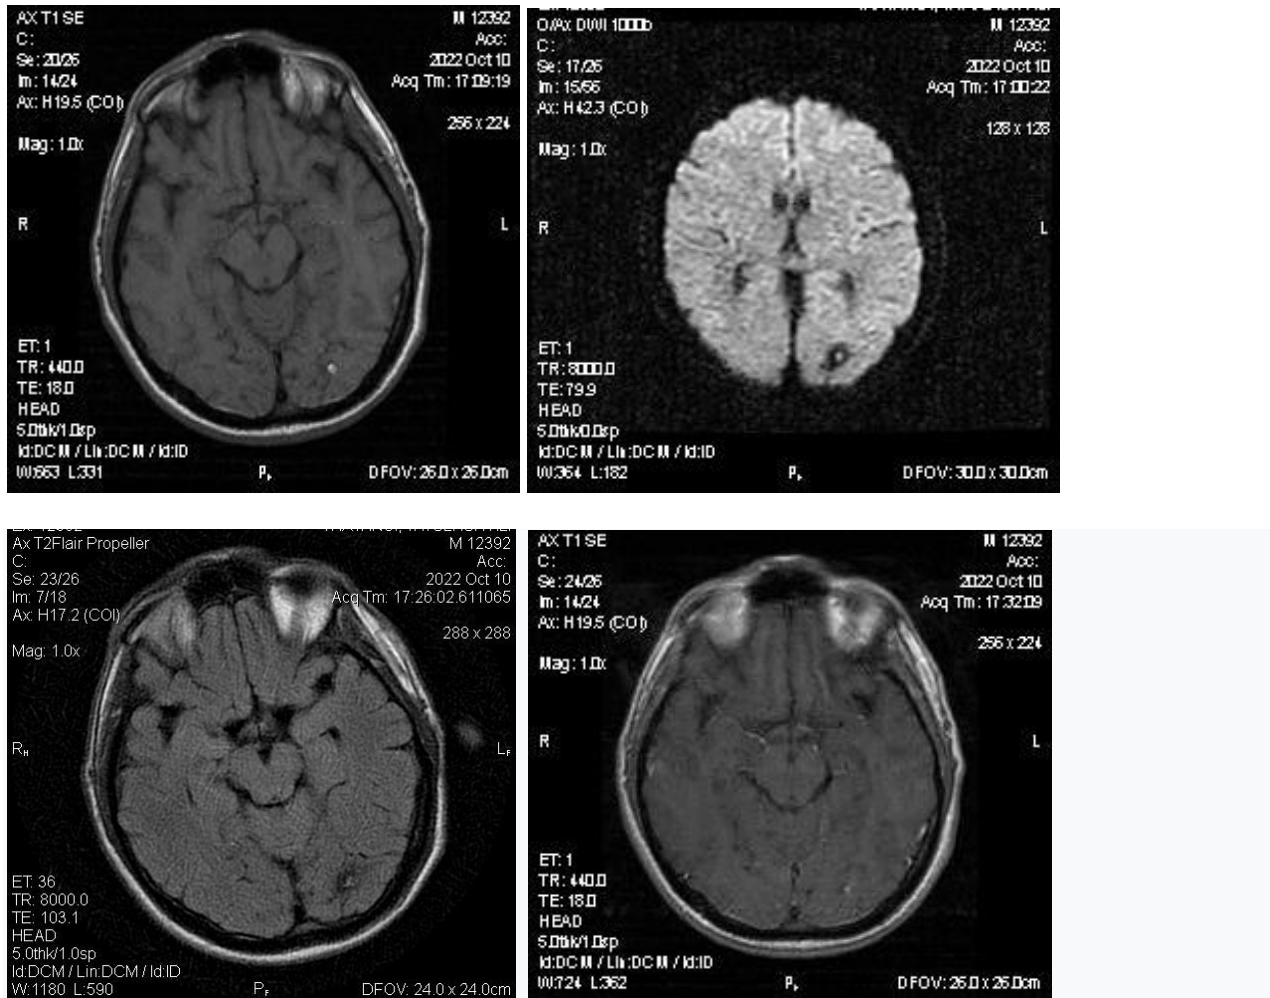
(10 .10 .22) MRI of the brain. Diffusion limited imaging.
